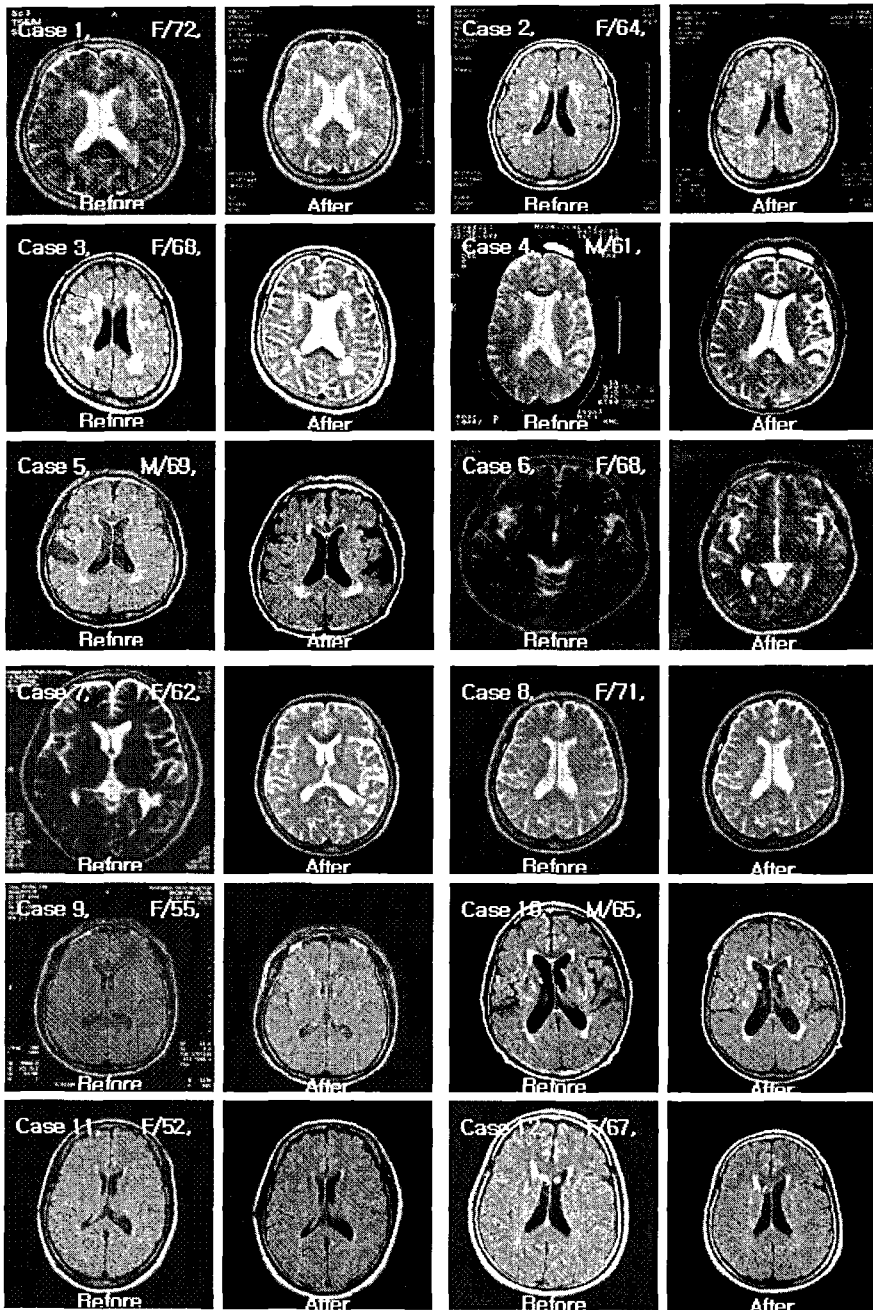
Brain MRI before and after 1 year of *Chunghyul-dan* medication in Cases 1 to 12
